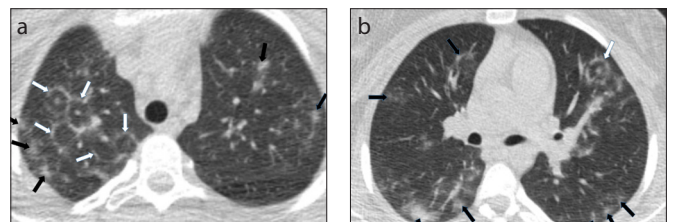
a, b. Axial thorax CT images (a, b) demonstrate multiple multifocal reversed halo signs (white arrows) with a centrilobular dot-like nodule. Multifocal peripherally distributed patchy alveolar infiltrations and ground glass opacities are noted bilaterally (black arrows).
